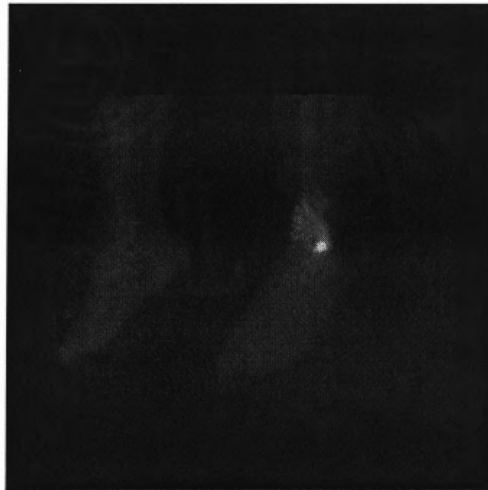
This is a planar scintigraphic image, originally saved in the DICOM format, of In-111 labeled white blood cells localizing in a painful left ankle. The regions that have the highest levels of radioactivity appear whiter in color.
